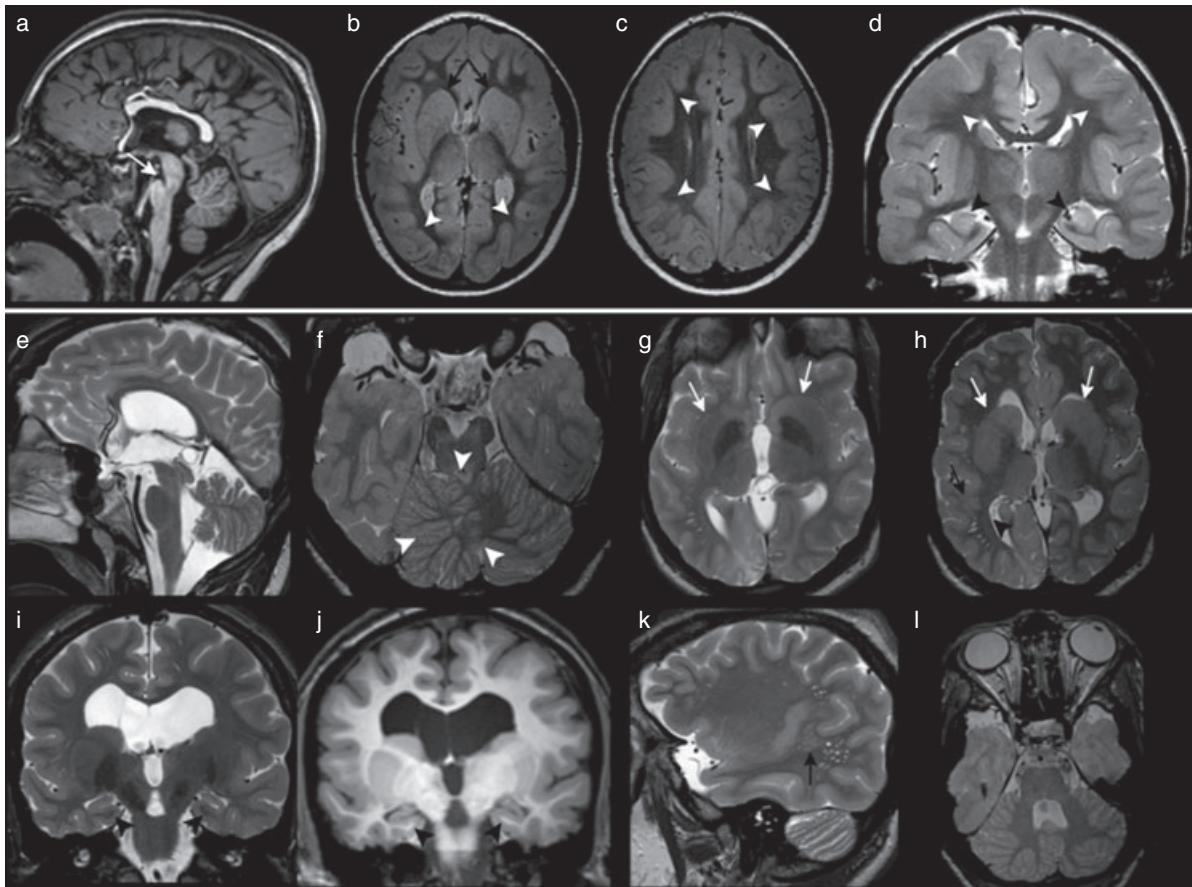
3T MRI findings: sagittal (a) and coronal (j) T1-weighted; and sagittal (e, k), axial (b, c, f, g, h, l), and coronal (d, i) T2-weighted sections. Patient 1 (a–d, 5y) showed a pachygyric cortex with diffuse subcortical band heterotopia (white arrowheads in b, c and d), irregular basal ganglia with a fusion between caudate nuclei and putamina, and a simplified aspect of the hippocampi (black arrowheads in d). In (a) the corpus callosum appears thinned and truncated, the anterior commissure is absent, and the midbrain is highly dysmorphic (the white arrow points at a thinned pontomesencephalic junction). Patient 2 (e–l, 31y) showed several brain abnormalities on 3T MRI: the cerebellar vermis is hypoplastic and there is an irregular disposition of the cortical folia in the upper paravermian region (white arrowheads in f); the basal ganglia have an abnormal shape with a poor definition of the anterior limbs of the internal capsules (white arrows in g and h); the hippocampi show a simplified pattern (i and j); the optic nerves are thinned (l). A very small heterotopic periventricular nodule (black arrowhead in h) associated with an area of heterotopia in the white matter above (black arrows in h and k) is also evident. The lateral ventricles are enlarged, the corpus callosum is thin, and the anterior commissure is absent (e). An area of gliosis is evident in the right occipital lobe (g and h).
